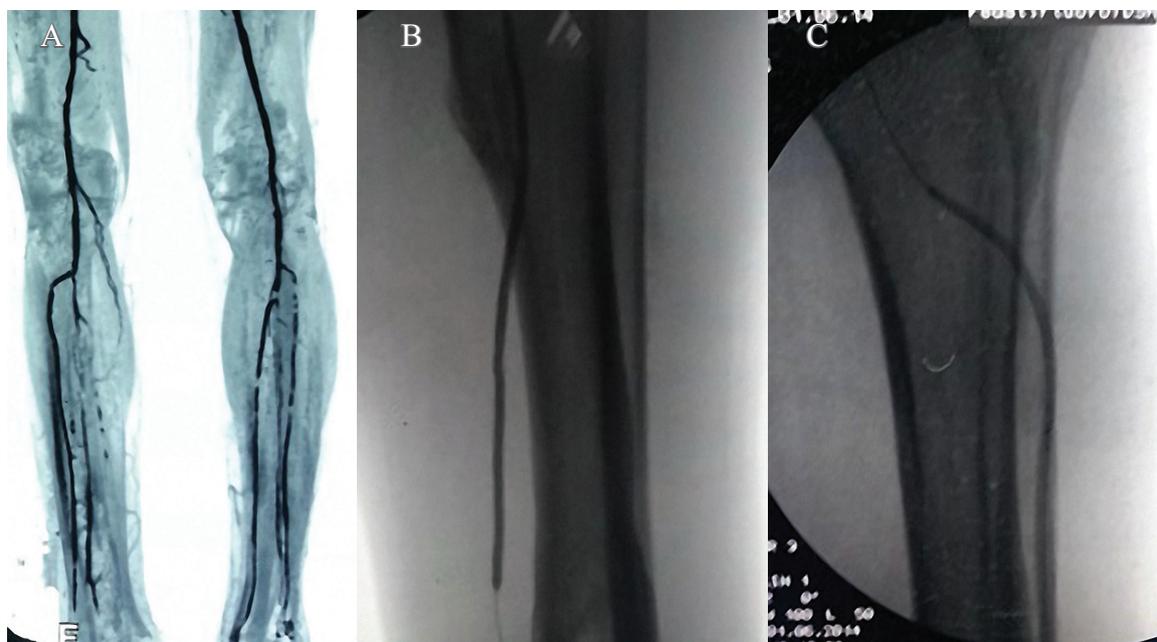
A: A CT angiography showing a multisegmental lesions involving the Anterior tibial, and posterior tibial vessels in a patient with left foot infected ulcer in need of urgent debridement. B: Dilatation of the posterior tibial artery using 3 x 200 mm balloon. C: Dilatation of the anterior tibial artery using 3 x 200 mm balloon.
